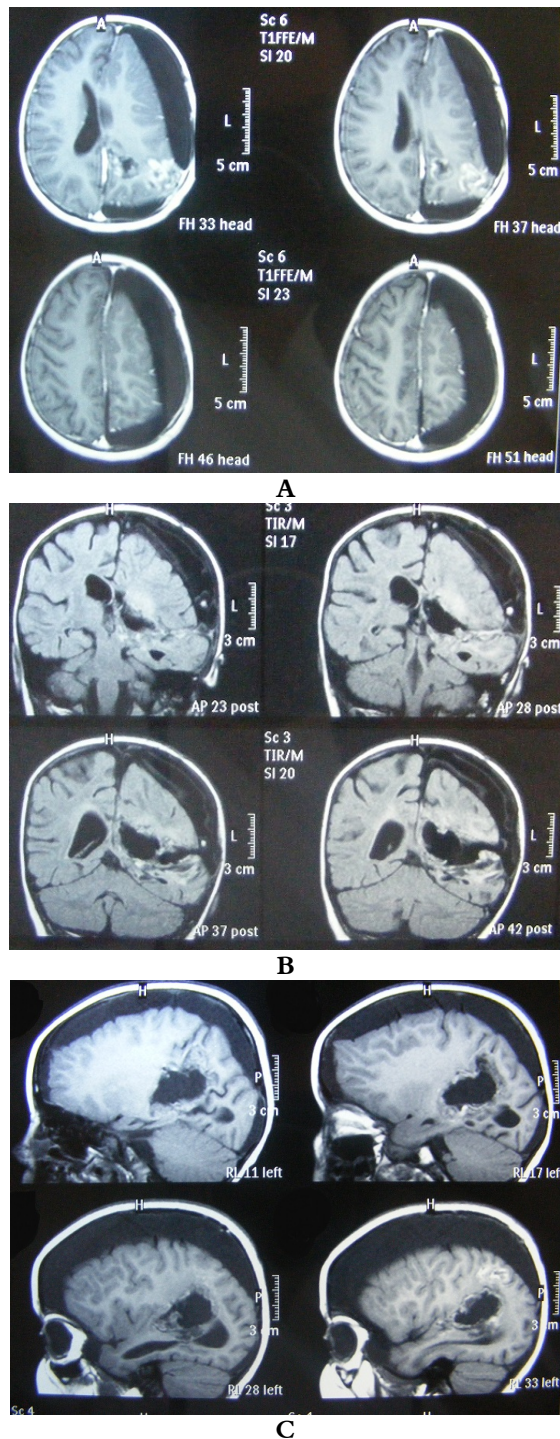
(A, B, C): One month postoperative MRI confirms the gross total removal, but also shows a compressive subdural hydroma.
